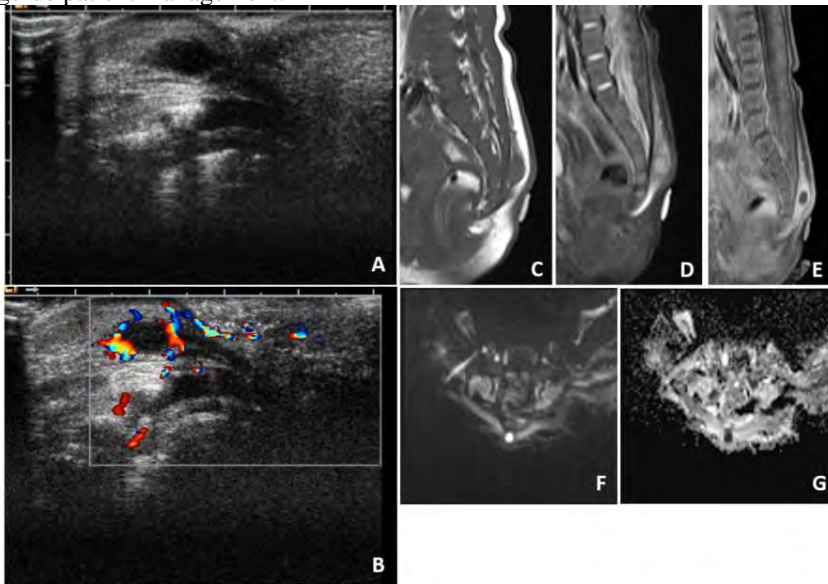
Figure showing the radiological findings of infected pilonidal sinus. A and B are the axial gray scale ultrasound and color doppler image of the tailbone depicting a cystic collection with color flow in the periphery. C to E is mid-sagittal MRI showing fluid filled rim enhancing tubular fistulous track. F and G demonstrate the sinus tract in axial plane with central restricted diffusion, in keeping with an abscess.
